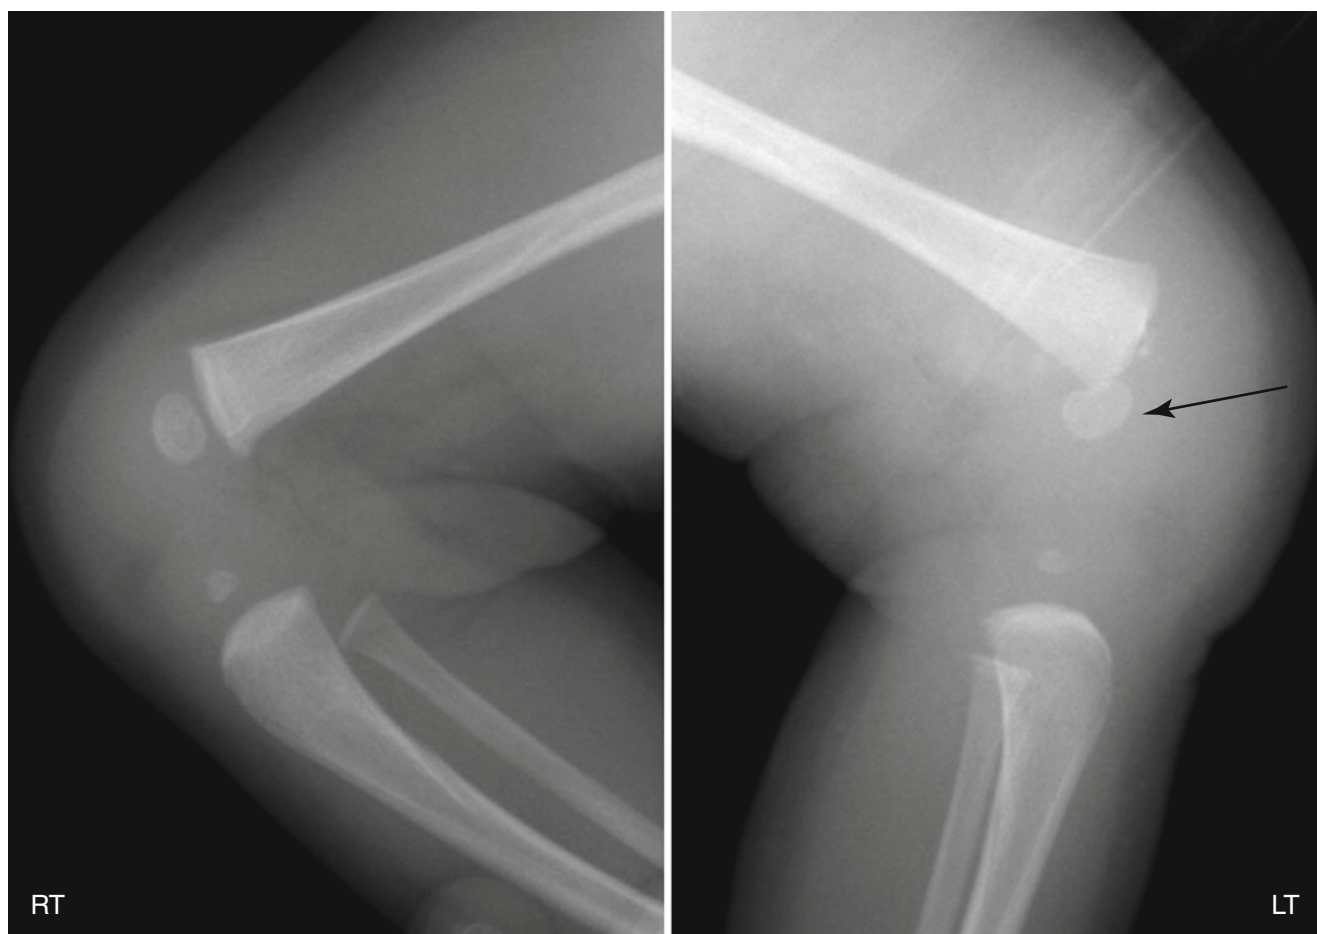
Salter-Harris type I fracture in a newborn baby.* Lateral radiographs of the knee show a complete posterior slip of epiphysis of the left distal femur (arrow) due to a fracture through the physis (Courtesy of Dr. Kim IO, Seoul National University Children's Hospital)
